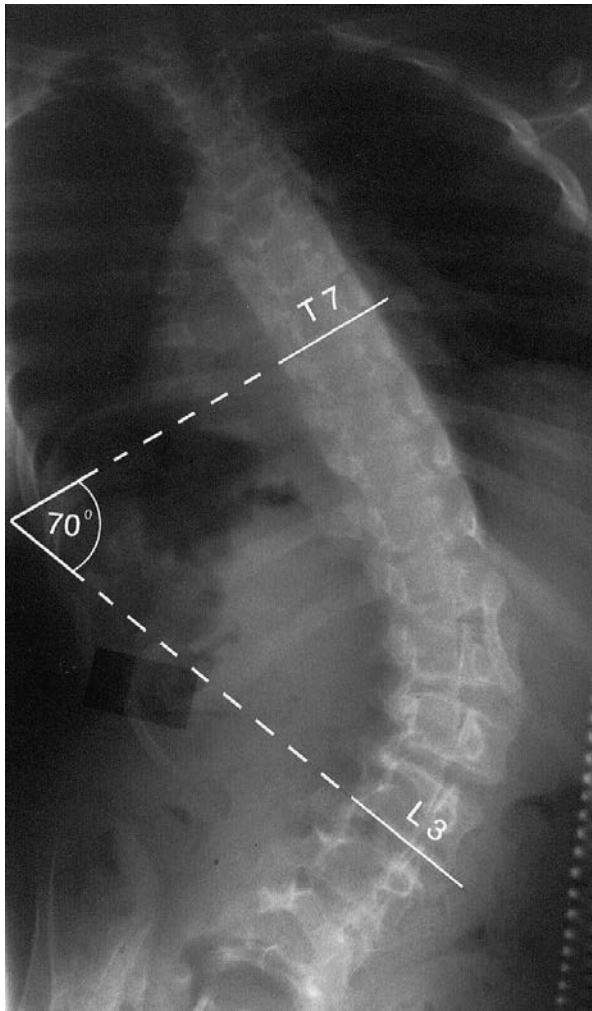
Plain antero-posterior spine X-ray showing thoracolumbar scoliosis in an adolescent with a spino-cerebellar syndrome. The Cobb angle drawn between the apices of the curve measures 70 degrees.
